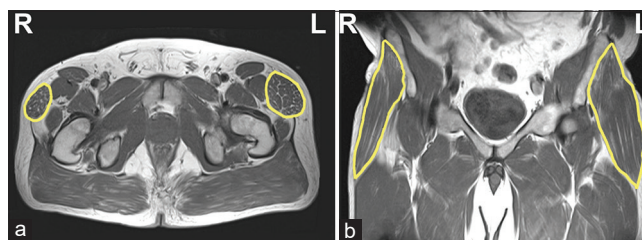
(a) Axial and (b) coronal pelvic MRI scans demonstrating the hypertrophic tensor fascia lata (yellow) on the left as compared to the right side.
